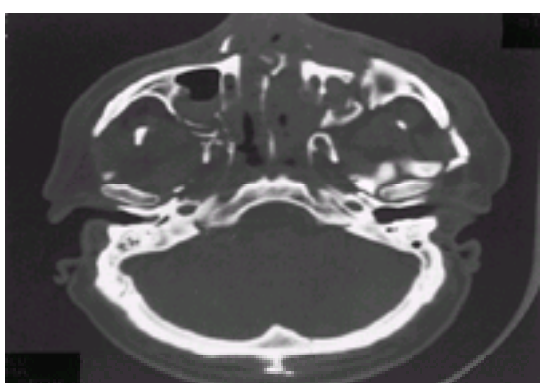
Axial CT scan provides the most precise information about the facial skeleton.
